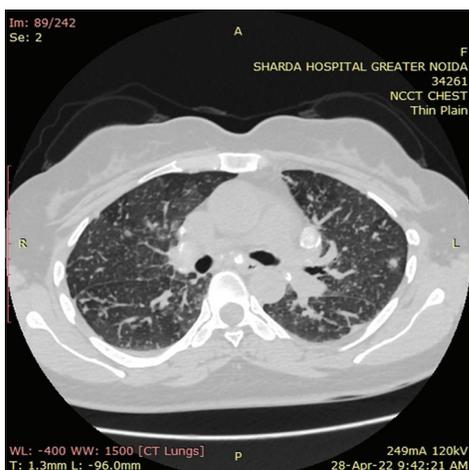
CT scan lung window (axial image) shows multiple nodular opacities in the upper and lower lobes on both the sides
